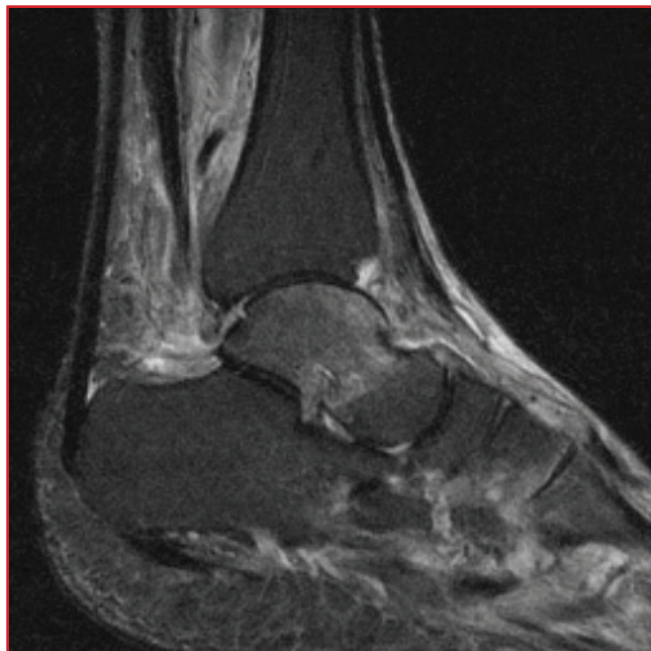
T2-weighted MRI image of the patient on presentation. Note edema of the talus and synovitis of the ankle joint and joint effusion.
